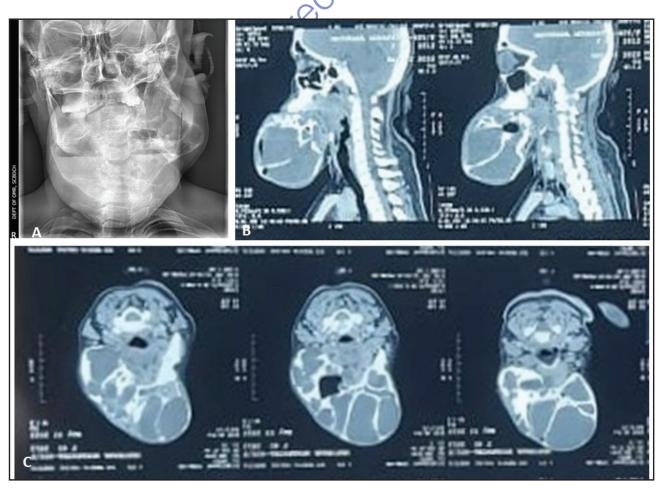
A, B, and C Radiographic examination of the expansile lesion.
